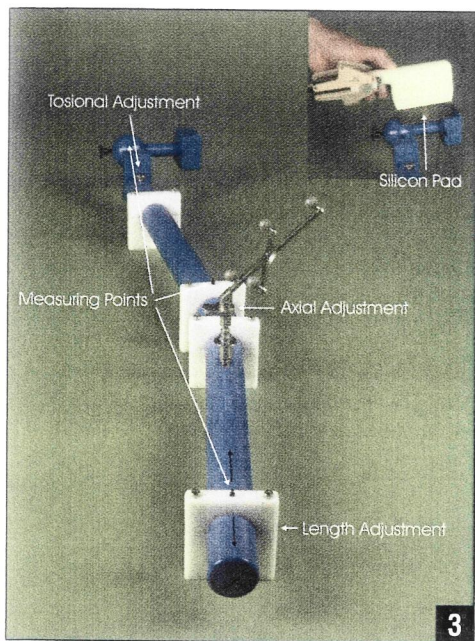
Model for testing the accuracy of the new universal ultrasound measuring system. The model allows for adjusting length, torsion, and axis of the leg in its clinically relevant sections to any chosen position. The ultrasound probe is coupled to the plastic leg via a silicone pad.
